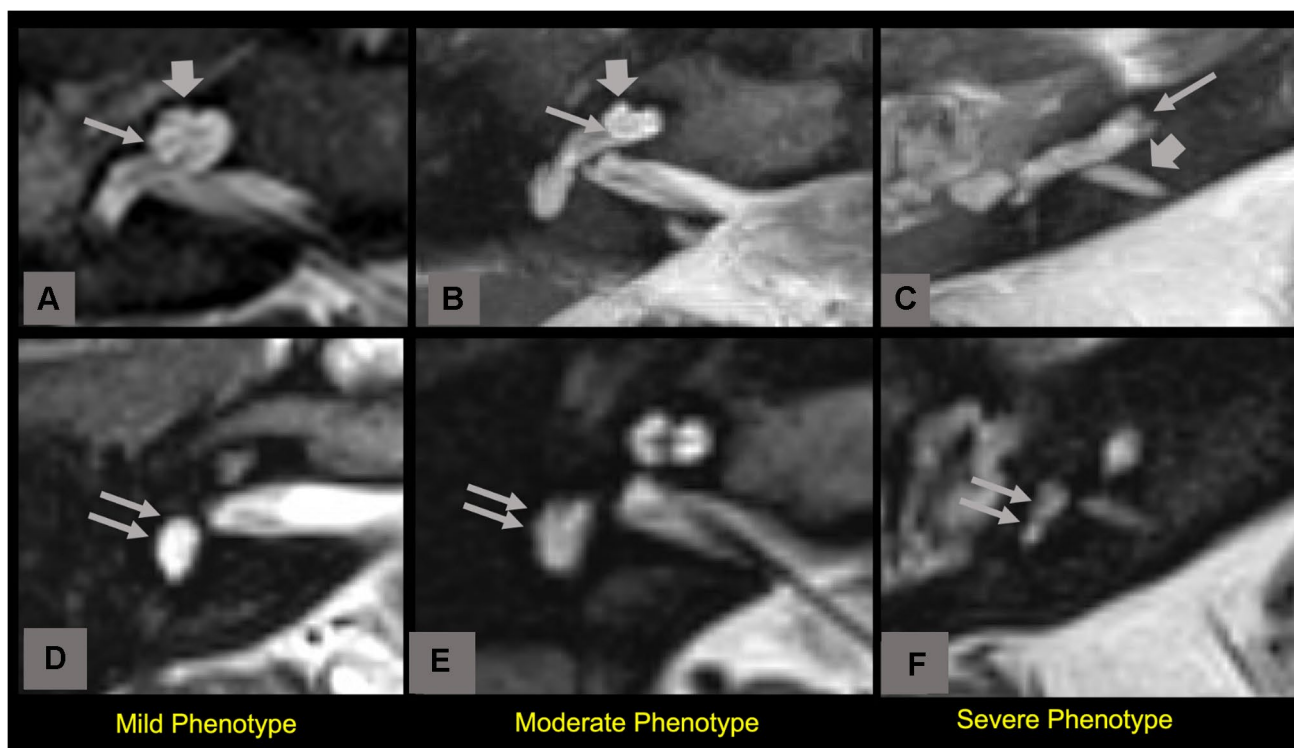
MRI appearances of the cochleae and vestibule/semicircular canals in 3 CHARGE patients with different degrees of cochlear hypoplasia (CH). A Mild phenotype: the first half of the basal turn is present and normal, the second half of the basal turn is complete with well-visualized basilar membrane/osseous spiral lamina complex (thin arrow), the upper part of the cochlea is hypoplastic (thick arrow). B Moderate phenotype: the first half of the basal turn is present and normal; the second half of the basal turn is present but
